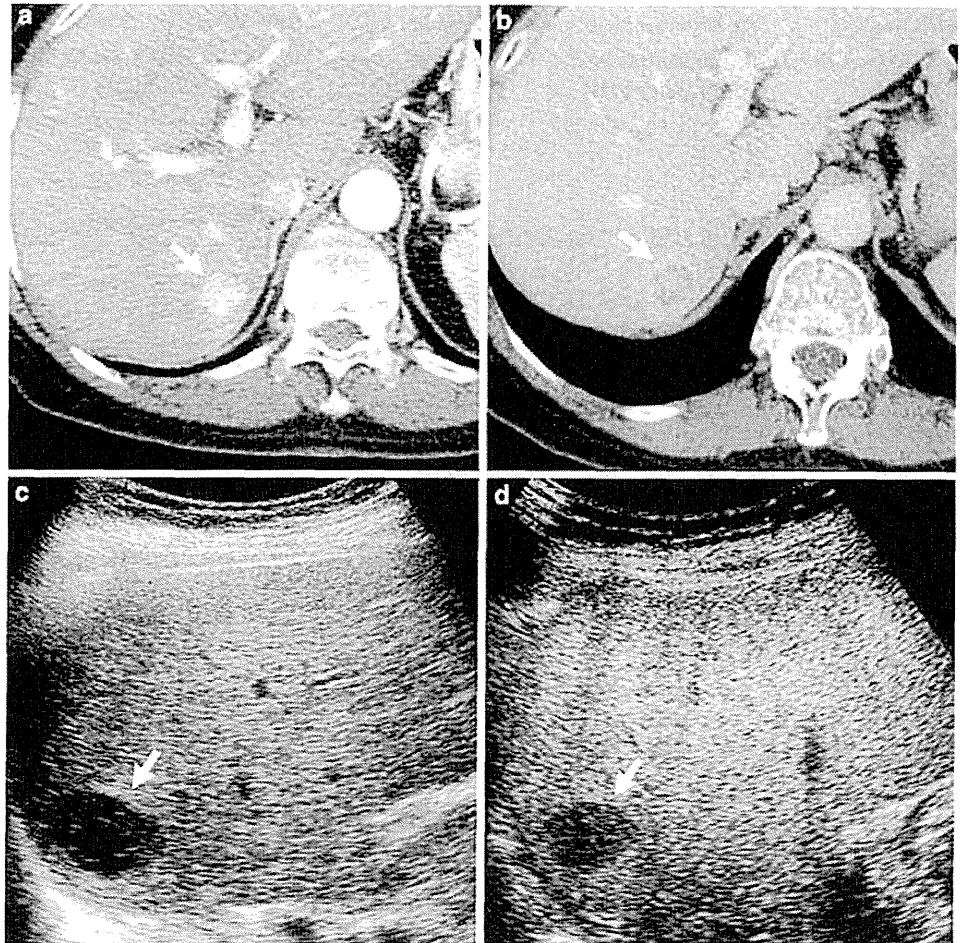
Typical appearance of HCC (*arrow*) on dynamic CT and unenhanced and enhanced US. Appearance of HCC on dynamic CT [early enhancement (a) with late washout (b)]. The nodule was detected as a hypoechoic lesion by unenhanced US (c) and visualized as an enhancement defect in Kupffer imaging Sonazoid CEUS (d)
